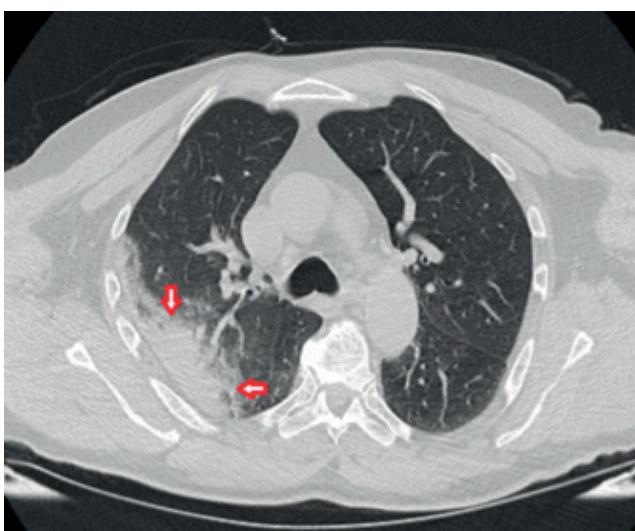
The thorax (CT) taken afterwards, a consolidated field with air bronchogram was observed in the right lung upper lobe posterior segment.
